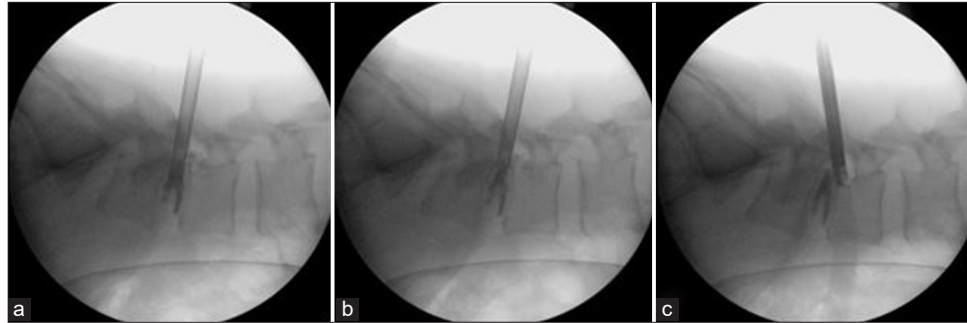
(a-c) Intraoperative X-ray documentation of the foraminal retreat maneuver starting in the center of the disc.
